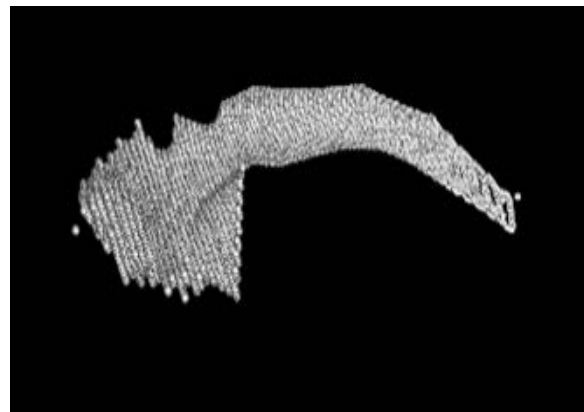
MRI 3D Reconstruction (Manual Tracer)
